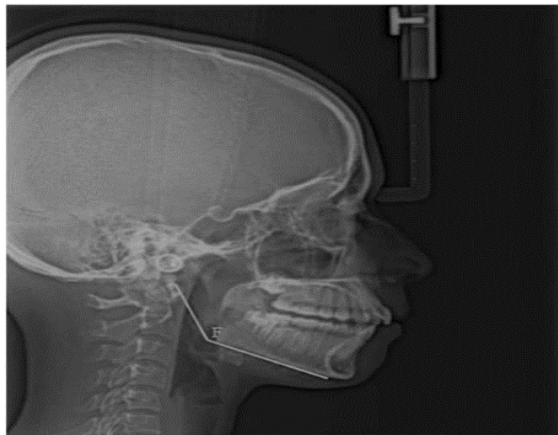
Measurements taken on lateral cephalometry radiograph
